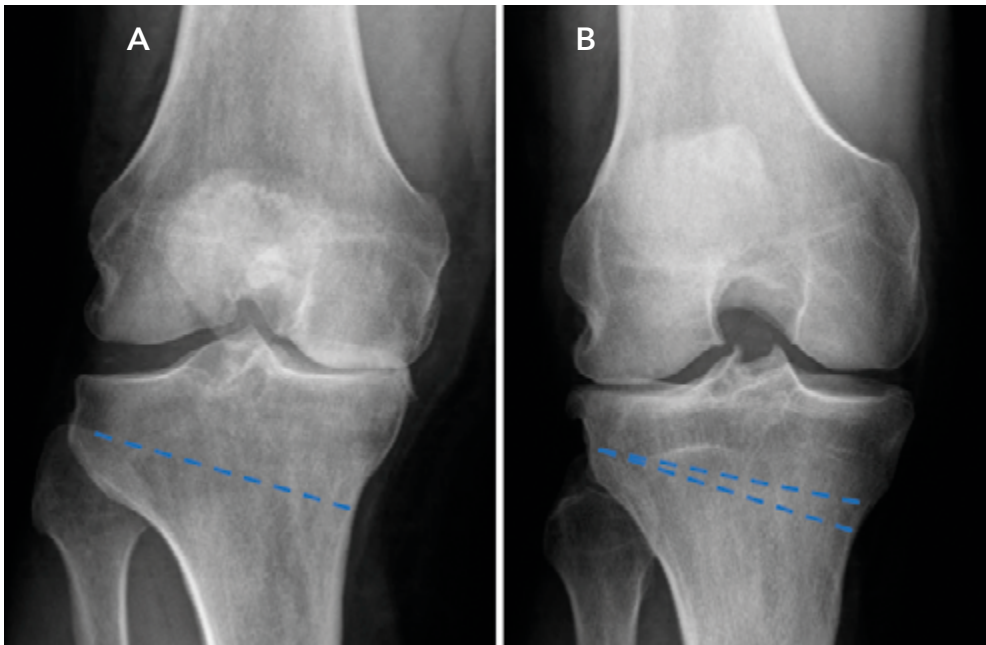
Preoperative anteroposterior radiographs of high tibial osteotomies (HTOs) with projected osteotomy cuts (striped lines). A Right knee before medial opening wedge HTO. B Right knee before medial closing wedge HTO.
